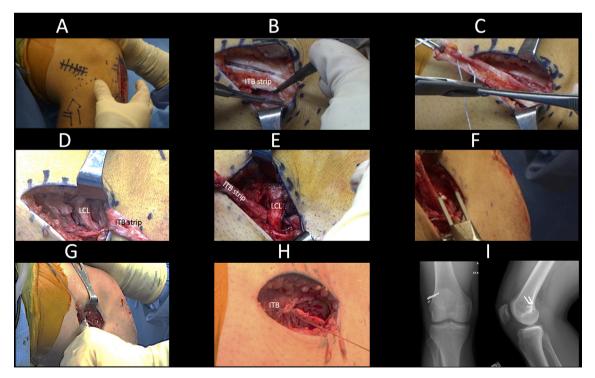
Modified LET technique. (A) The lateral incision is planned centred on the distal ITB. The surgeon's thumb is localising Gerdy's tubercle. (B) A full thickness 10×80 mm strip of the central one-third of the ITB is dissected. (C) The proximal end of the ITB strip is secured with non-absorbable sutures. (D) The LCL is identified. (E) The ITB strip is shuttled deep to the LCL. (F,G) A staple is used to secure the ITB strip to the lateral femur epicondyle with the appropriate amount of tension. (H) The ITB defect is closed proximally, but a portion is left open distally to no overtension the repair. (I) Anteroposterior and lateral X-rays after an ACLR+LET procedure demonstrating the appropriate location of the staple. ACL, anterior cruciate ligament; AM, anteromedial; ITB, iliotibial band; LCL, lateral collateral ligament; LET, Lemaire lateral extra-articular tenodesis.
